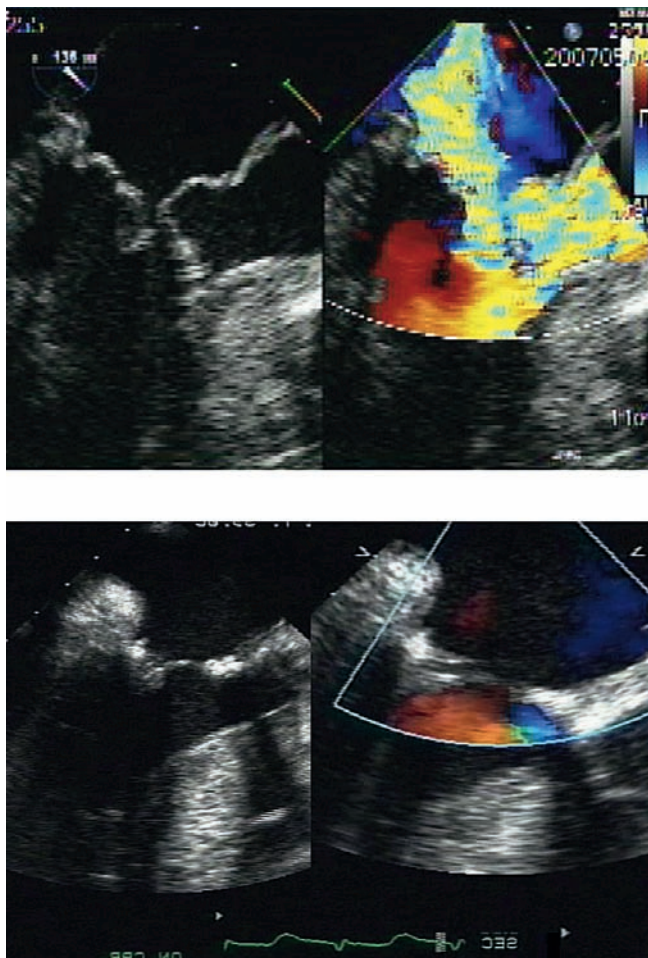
Top panels: Preoperative transesophageal echocardiogram showing SAM, anterior papillary muscle prolapse into the left ventricular outflow tract (LVOT), severe mitral regurgitation and a 185 mmHg outflow tract gradient. Bottom panels: Intraoperative transesophageal echocardiogram after repair showing a fully open LVOT, no SAM, no residual MR and a negligible outflow gradient.
